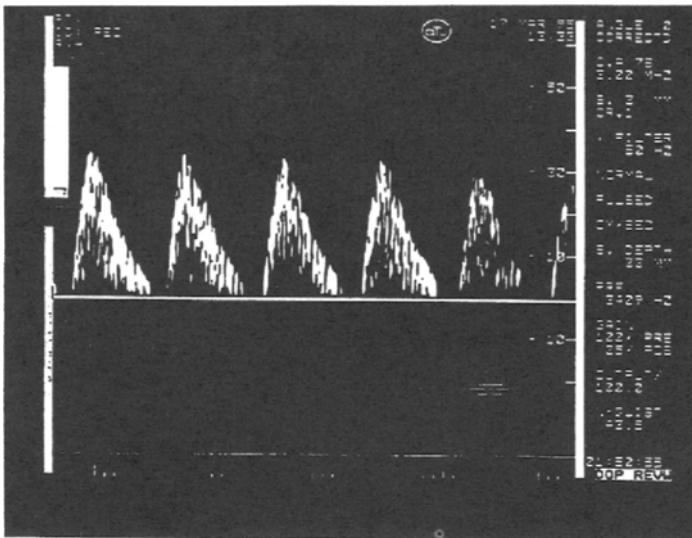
Doppler waveform pattern of abnormal ductus venosum venous blood flow suggestive of fetal cardiac compromise.
